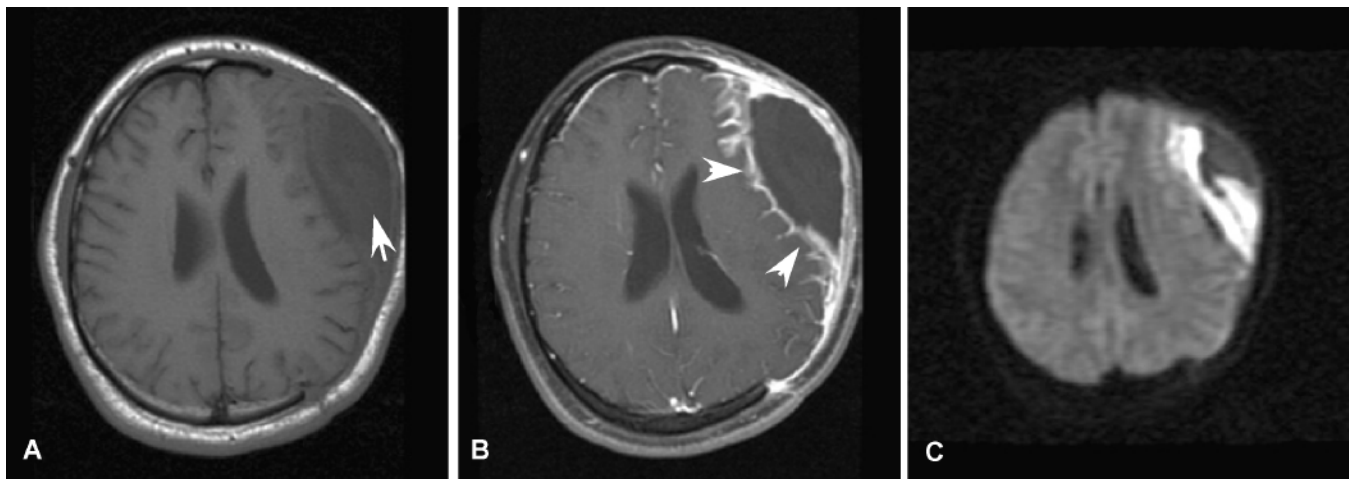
Extraaxial empyema. A: A T1-weighted MR image showing a subdural collection (arrow). B: A T1-weighted Gd-enhanced MR image demonstrating rim enhancement (arrowheads) of the collection. C: Diffusion weighted image with bright signal that is diagnostic of a subdural empyema.
